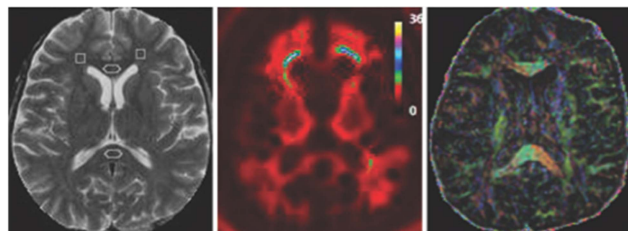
T2-weighted MRI (left) with ROIs in the forceps minor (squares) and genu & splenium of corpus callosum (ovals), scaled texture similarity map (middle), and fractional anisotropy map (right) from the same subject.
